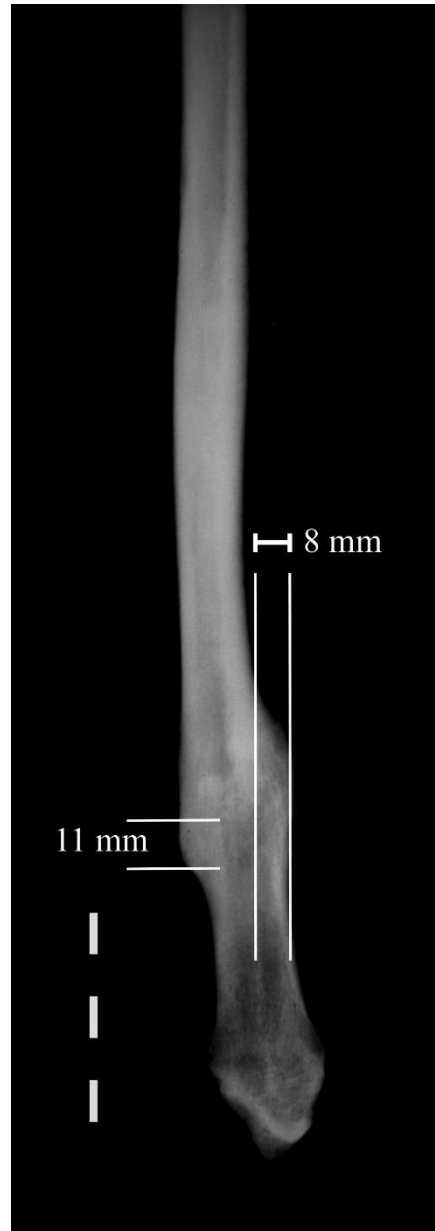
Healed fracture with displacement and overlap is measured using a ruler placed on the radiograph. This image represents an oblique fracture to the left fibula of individual 2008.14.434. The distal segment is displaced by 8mm towards the anterior, resulting in a calculated apposition of 56%. The fracture segments have an overlap of 11mm.
